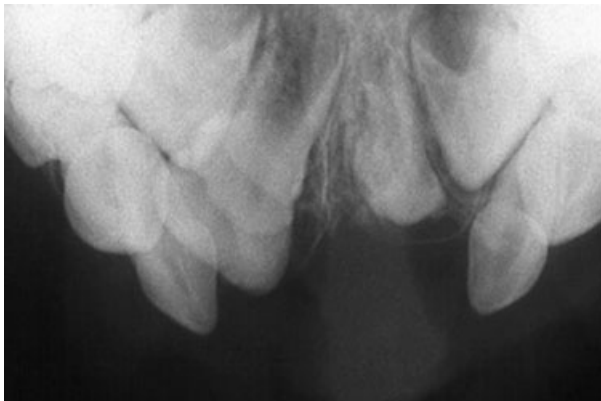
Radiographic aspect after 3 years. Malformation in the crown of the right central permanent incisor and complete alteration in the shape of the left central permanent incisor.
